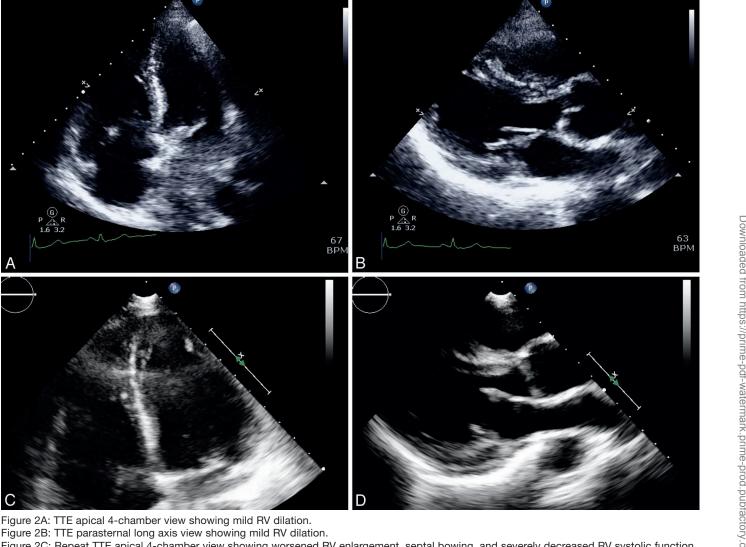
Repeat TTE apical 4-chamber view showing worsened RV enlargement, septal bowing, and severely decreased RV systolic function. Figure 2D: Repeat TTE parasternal long axis view showing RV enlargement and septal bowing.
